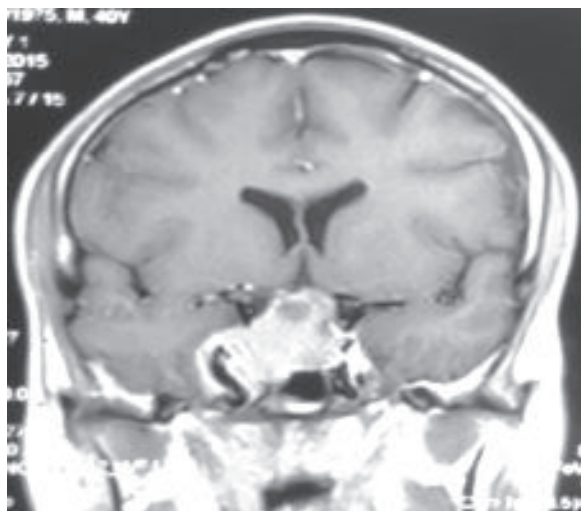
MRI of Brain Contrast/ Coronal: mild ring enhancement of lesion seen in sellar/supra-sellar compressing the internal carotid arteries and optic chiasma.
